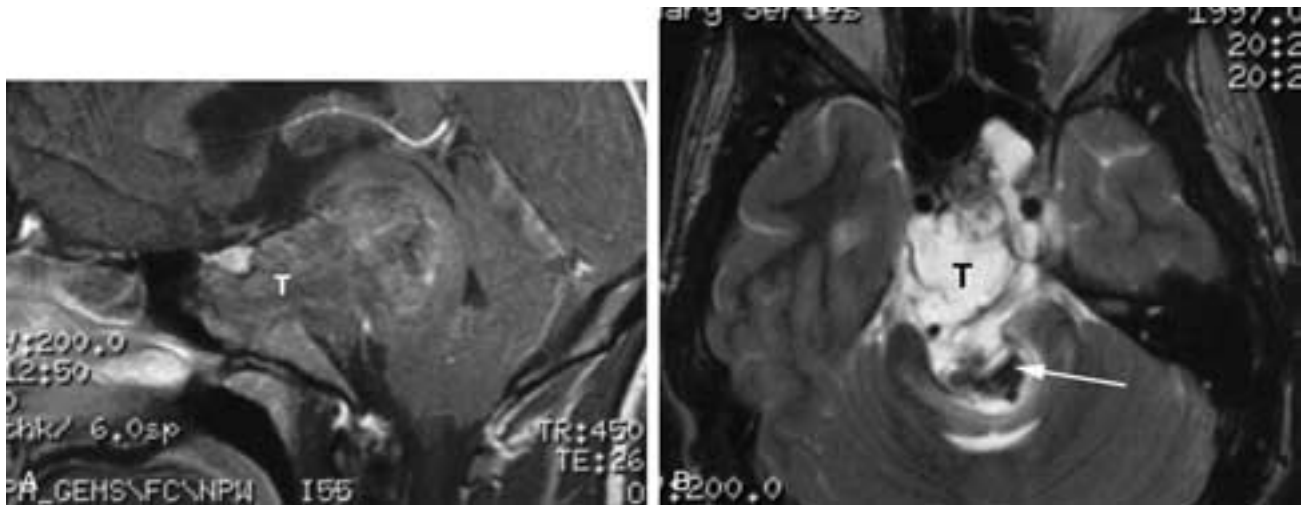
Chordoma of the basisphenoid. A, Postcontrast sagittal T1 image shows low enhancement of the tumor (*T*). Note how the lesion pushes posteriorly into the pons. B, Axial T2-weighted image shows the general high signal of the tumor (*T*), but there is an area of low signal representing hemosiderin from previous hemorrhage (*arrow*).
